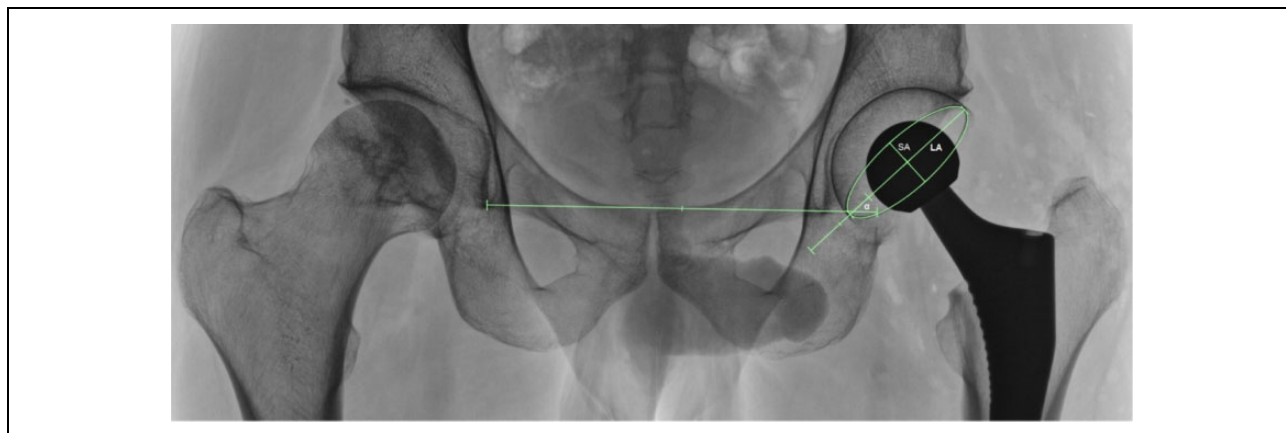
Example of an AP pelvic radiograph in a post-operative THA patient with the measurements used to calculate acetabular component position superimposed over the radiograph. AP: anteroposterior; α : inclination; LA: long axis; SA: short axis; THA: total hip arthroplasty.
